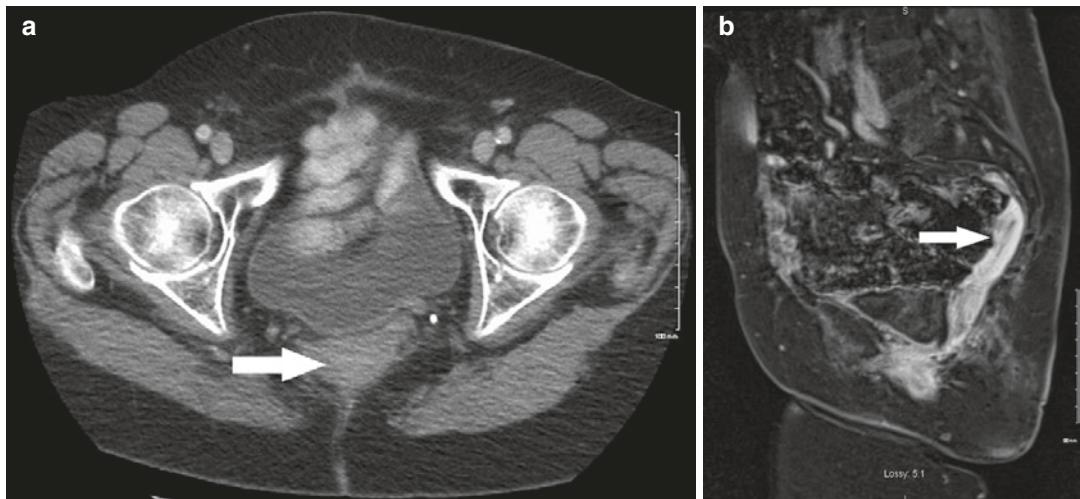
(a) Axial CT image of a 57-year-old woman who had surgery for rectal cancer 2 years earlier presenting with upper abdominal pain. CT shows some soft tissue anterior to the sacrum that was called tumor recurrence
